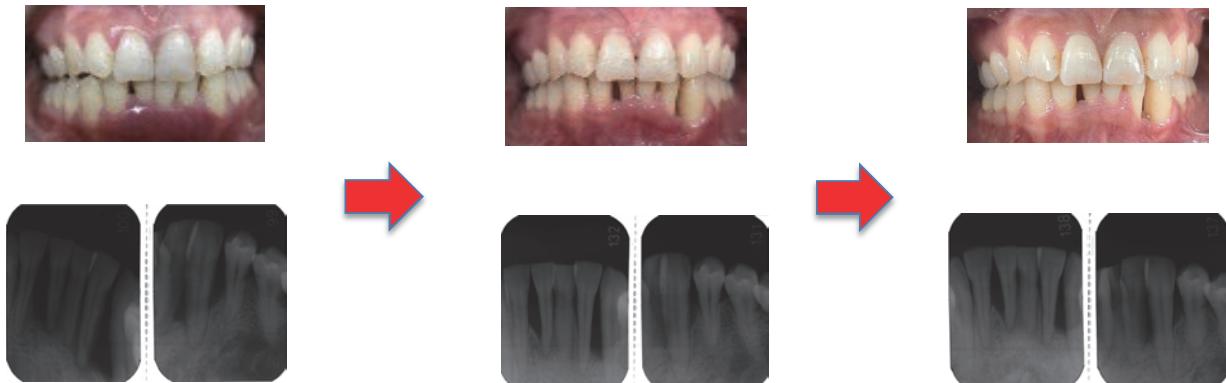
The periodontal condition of anterior lesion was focused in Fig 13a – f. The X-ray showed alveolar bone regeneration and improved gingival inflammation.
